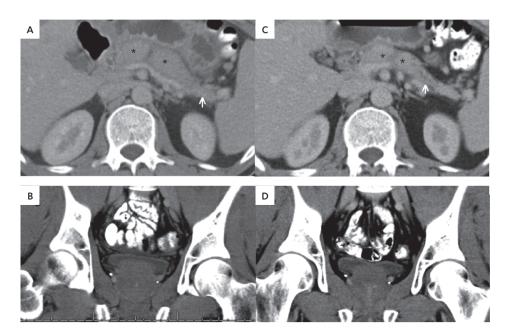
Contrast enhanced abdominal CT in a 39-year old man before and after steroid treatment 2 months later. (A) Sausage-shaped pancreatic body (*) with subtle hypodense capsular rim. The pancreatic tail (short white arrow) is relatively atrophic. (B) Enlarged prostate (51 x 49 x 49 mm) of homogeneously low density. (C) After steroid treatment the pancreatic body (*) has decreased to normal size, although still with loss of normal lobularity. Note irregular and slight pancreatic duct dilatation in atrophic tail (short white arrow). (D) Decrease of prostate enlargement (45 x 47 x 44 mm) and return of zonal distinction after steroid treatment.
